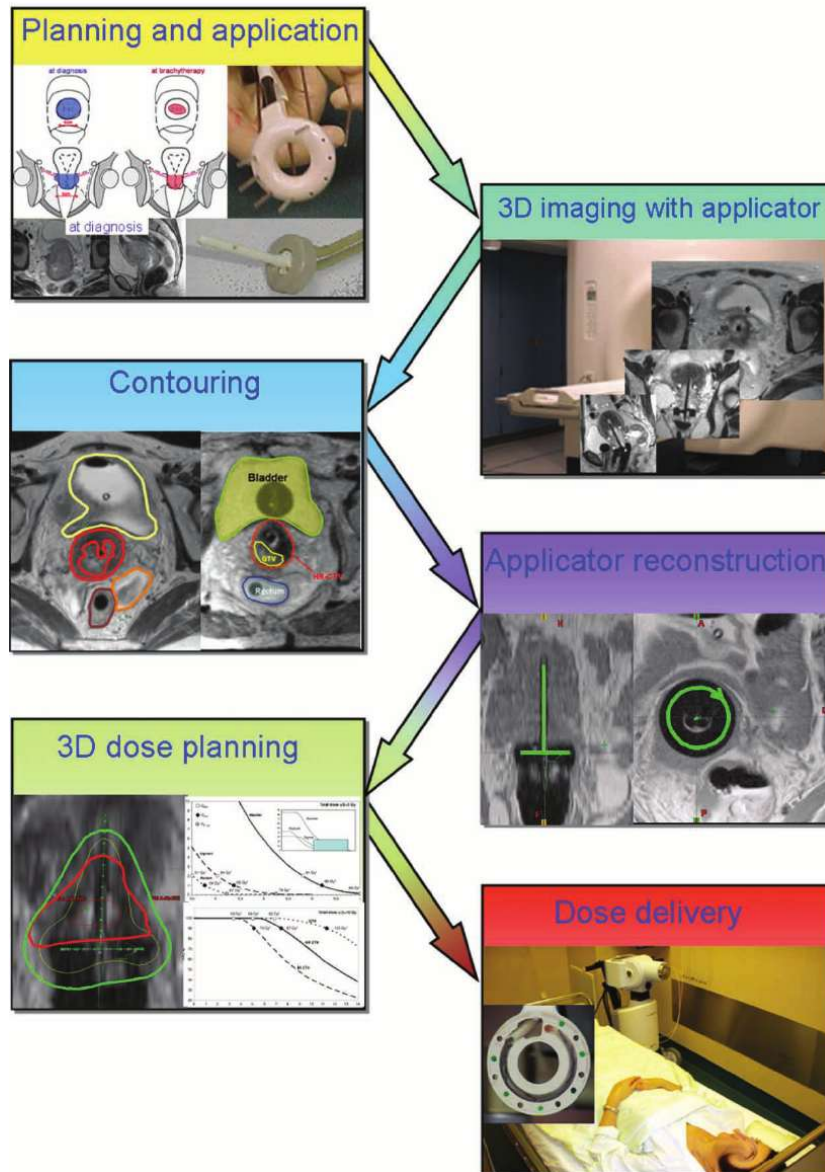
Treatment chain for 3D image-guided adaptive cervix cancer brachytherapy using MRI. Reproduced from Pötter R, Kirisits C, Fidarova E, Lindegaard JC. *Image-guided adaptive brachytherapy for cervix cancer: present status and future*. Radiother Oncol. 2009 [Figure 2]. Available under fair-use for educational purposes.
